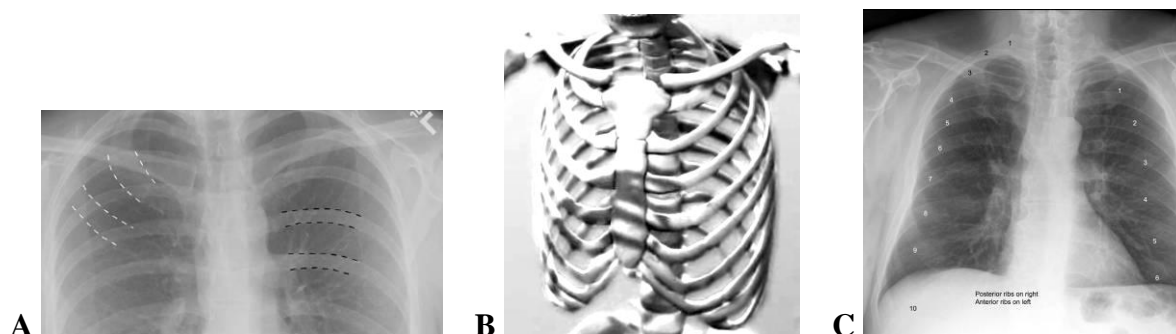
(A) Frontal radiograph upper chest shows that the posterior ribs (outlined in black) have a horizontal course, while the anterior ribs (outlined in white) have a more sloping course as they move medially. The anterior ribs are generally not seen as well as the posterior ribs. (B) Model bones of chest. (C) Frontal radiograph chest indicate marked anterior part of the ribs (left side chest) and posterior part of the ribs (right side)
